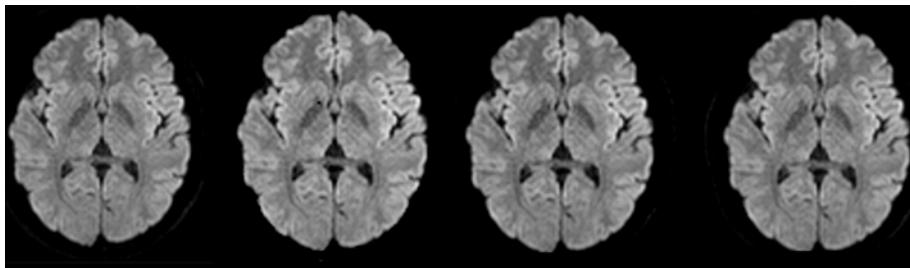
DWI isotropic images acquired in 6 directions. From left to right: Default DWI iso image without diffusion registration being used. Postprocessed DWI iso map without diffusion registration being used. Default DWI iso image with diffusion registration being used. Postprocessed DWI iso map with diffusion registration being used.
